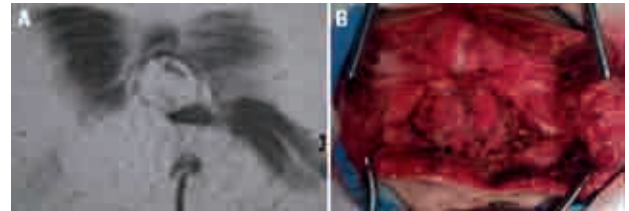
[A] T1-weighted MRI showing penetration of the lipoma into the lumbar fascia. [B] Surgical view of the same patient, revealing lipoma penetrating the lumbar fascia.
